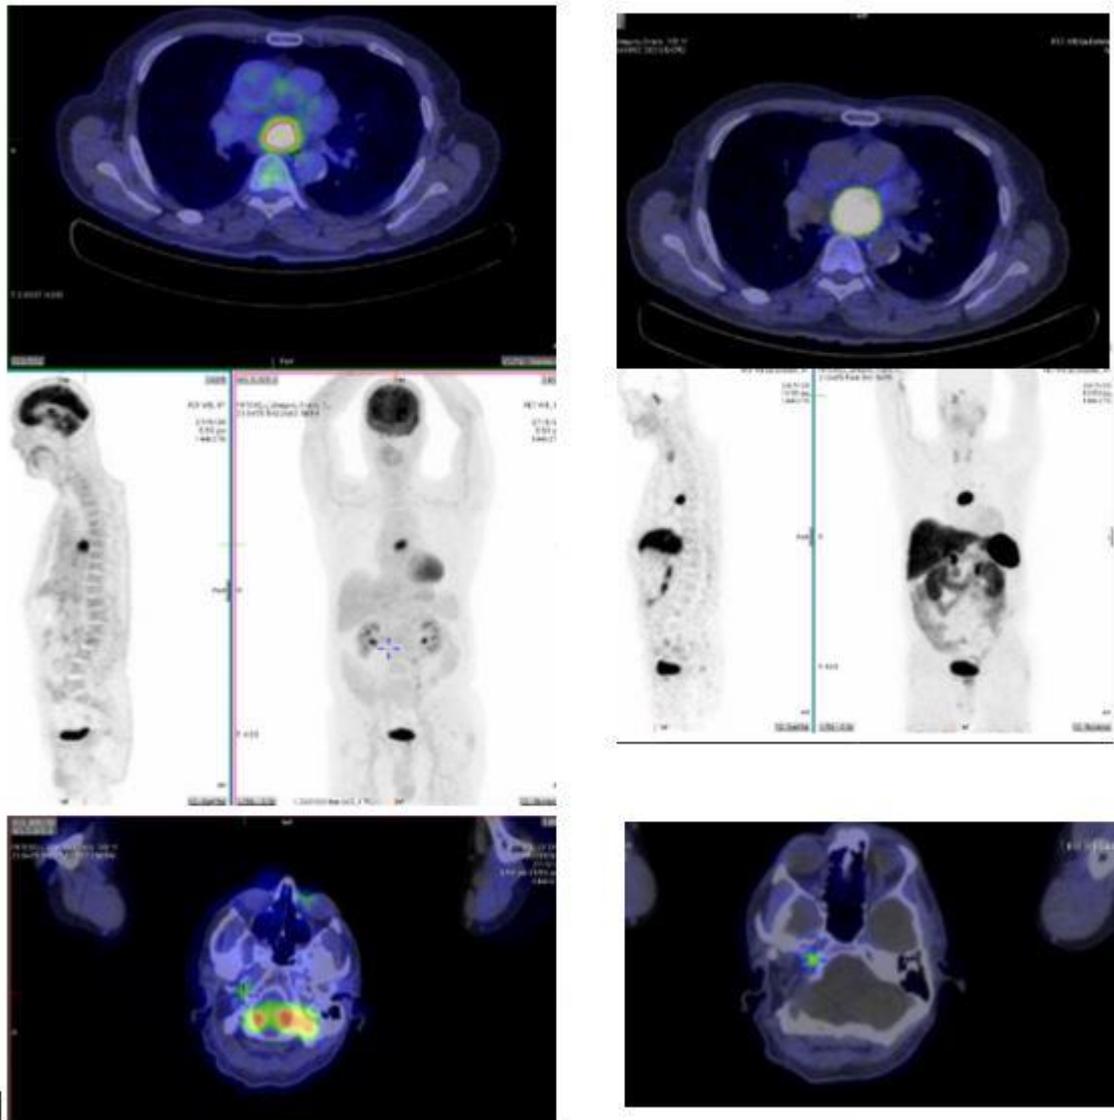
FDG- and DOTATATE-PET findings.
